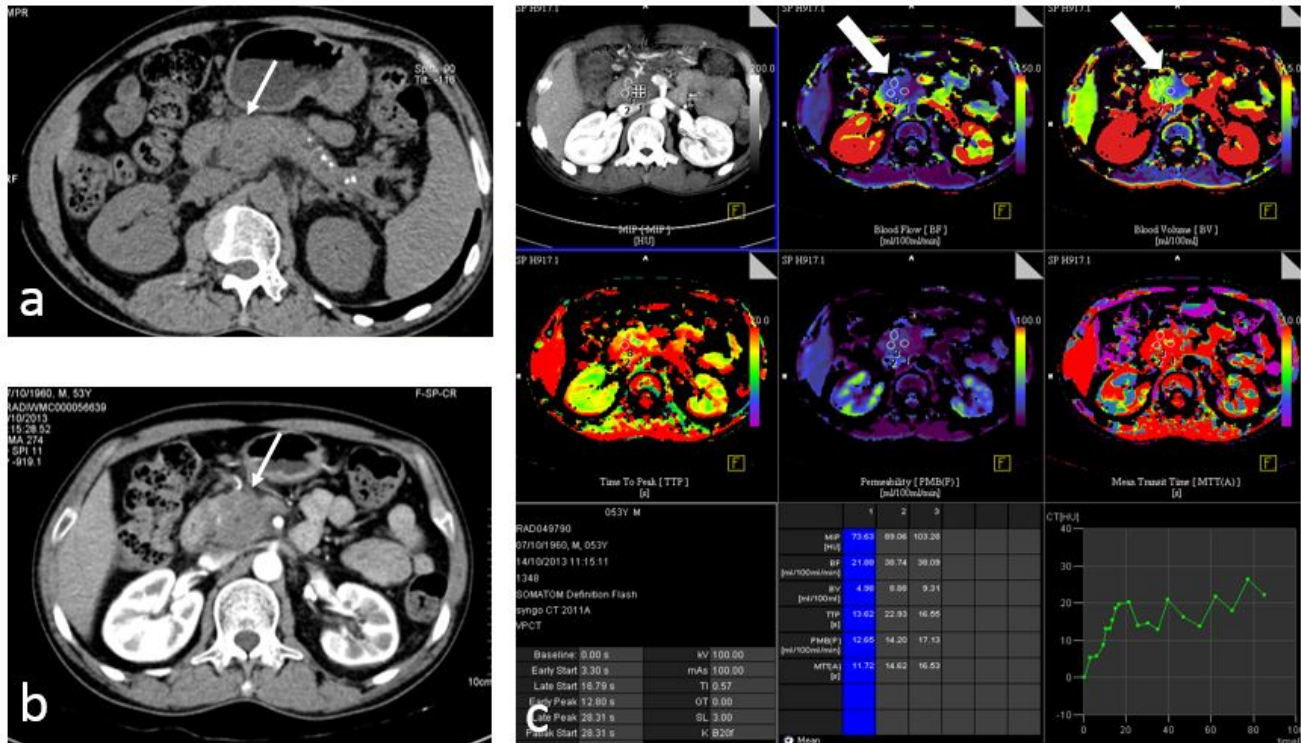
Axial non-contrast CT and contrast enhanced CT (a,b) of a patient with CCP shows an ill-defined hypoenhancing mass lesion in the head of pancreas (thin arrow). Perfusion CT of pancreas with color-coded maps depicting various perfusion parameters (c) shows that blood volume and blood flow are decreased (blue color) in the head region as comparison to the rest of pancreas (thick arrow) which is shown in green color. Although decreased perfusion parameters are also seen in pancreatic carcinoma, but the extent of decrease is significantly more in carcinoma. EUS guided sampling revealed only inflammatory cells suggestive of mass forming chronic pancreatitis.
